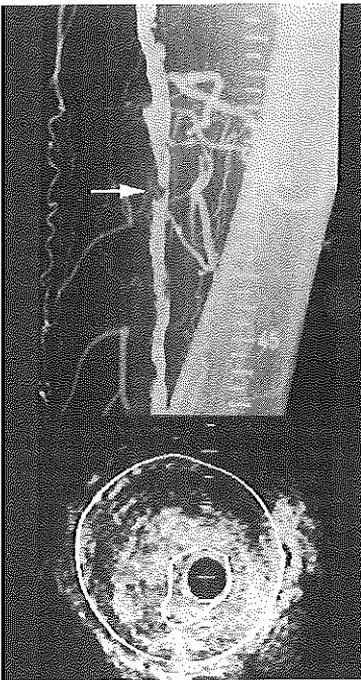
Intravascular ultrasound cross-section and angiogram obtained from a patient after angiographically defined non-successful balloon angioplasty (Group III). Vascular damage was not encountered (no effect = 360°). The free lumen area (FLA; inner contour) and media-bounded area (MBA; outer contour) display the quantitative results: FLA = 6.6 mm^2 , MBA = 56.6 mm^2 , plaque area = 50 mm^2 and free lumen diameter 2.9 mm. Two days later the patient was referred for bypass surgery. + = catheter; calibration = 1 mm.
